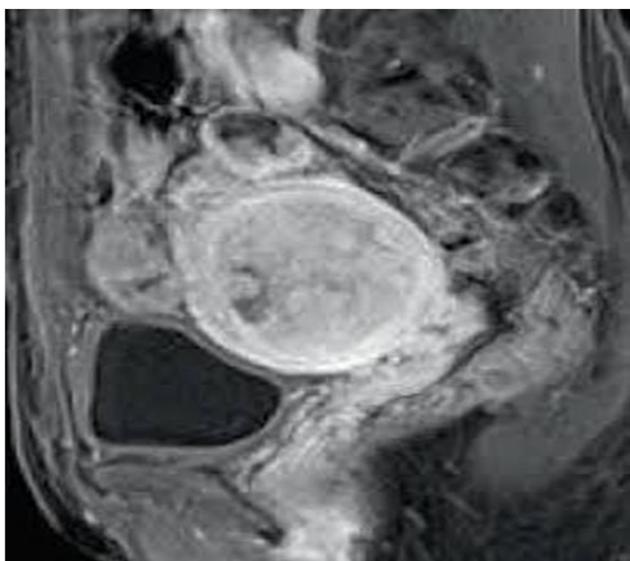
Contrast-enhanced computed tomography (CECT) of the abdomino-pelvic region revealed an enlarged uterus, measuring 15x14x10.5cm with well-defined uterine border and heterogenous enhancement of the solid cystic mass
